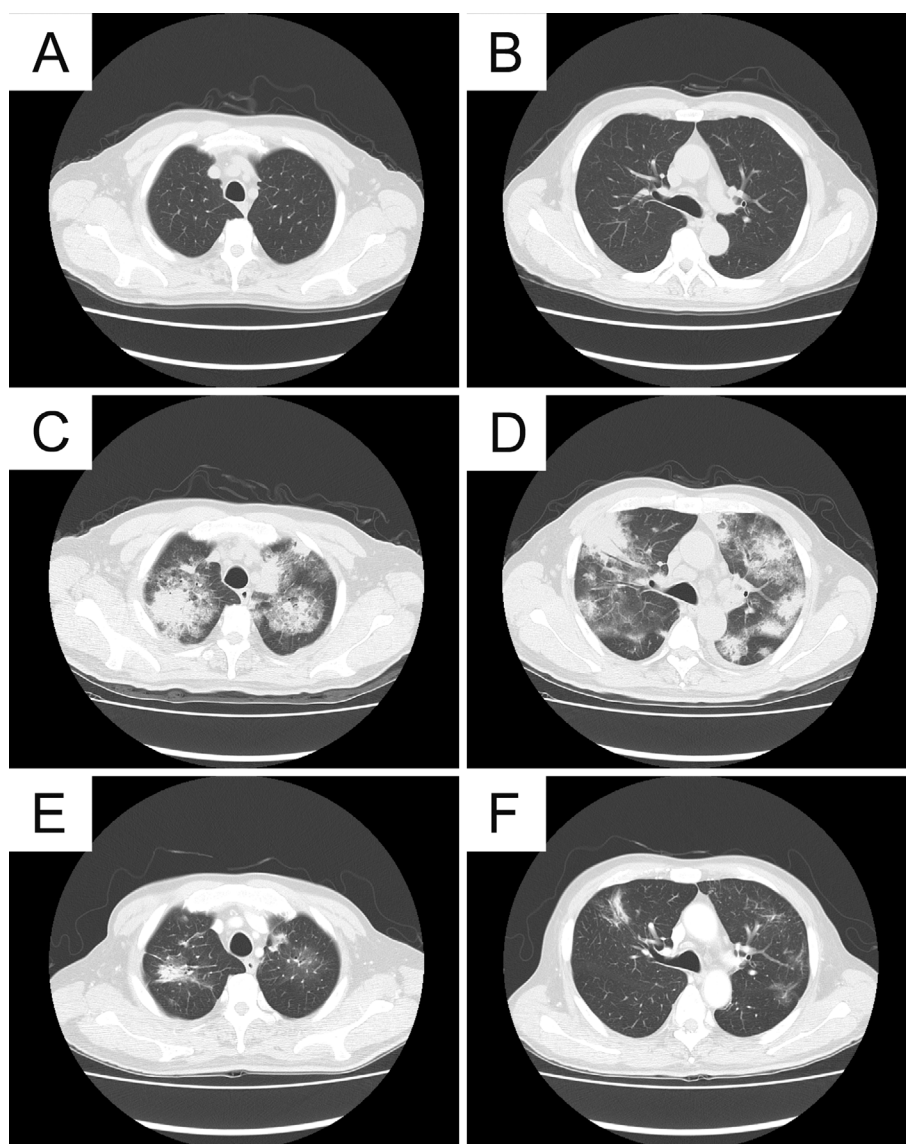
CT images. Chest CT images after treatment with nivolumab and at 15 weeks before the onset of dyspnea show normal findings (A, B). At the onset of ILD, multiple bilateral patchy infiltrates and ground glass attenuation with interlobular septal thickening developed (C, D). After treatment with corticosteroids, these findings all improved (E, F). ILD: interstitial lung disease
